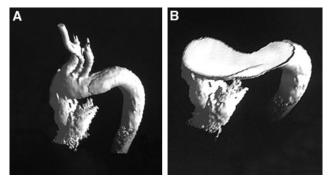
A and B, Three-dimensional reconstruction of angio-CT scan in patient affected by acute uncomplicated type B dissection.
